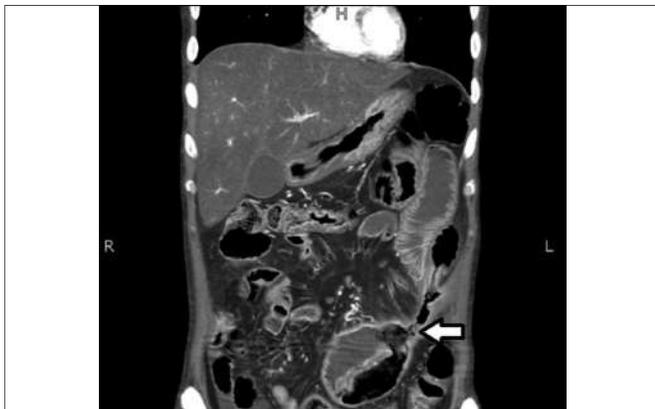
Same patient 5 months later coronal post-contrast CT scan demonstrating development of ischemic strictures in left-sided jejunal loops with multiple loops coalescing and forming enteroenteric fistula (arrow). There is resolution of bowel thickening and enhancement of bowel walls with dilated lumen proximal to stricture. Note development of fatty infiltration of liver.
